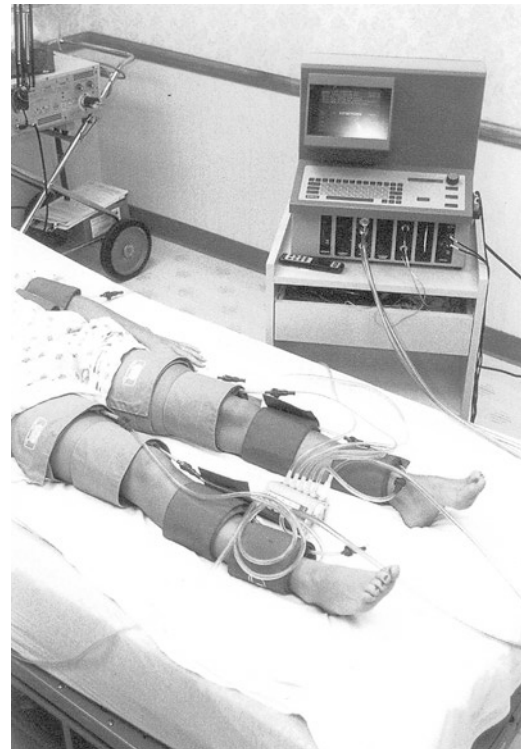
Technique for measuring the segmental Doppler pressures using the four-cuff method
